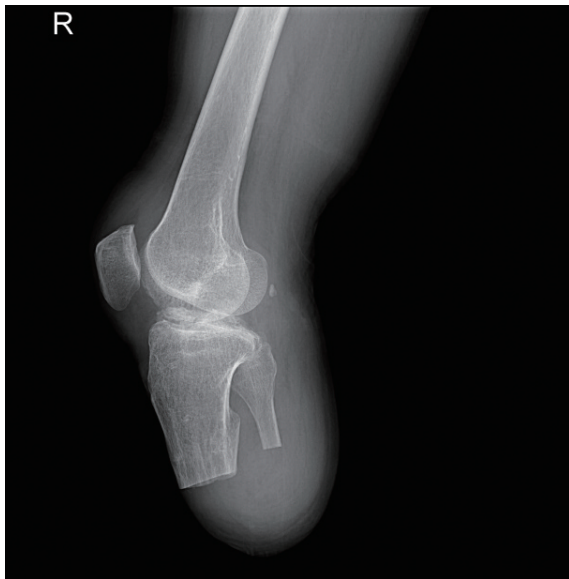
Amputation below right knee X-ray
